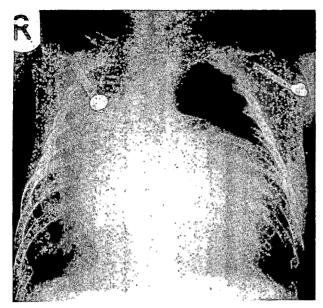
Chest radiograph before tracheal intubation showing cardiac enlargement, tracheal deviation to the right and hyperlucency of the left lung.
